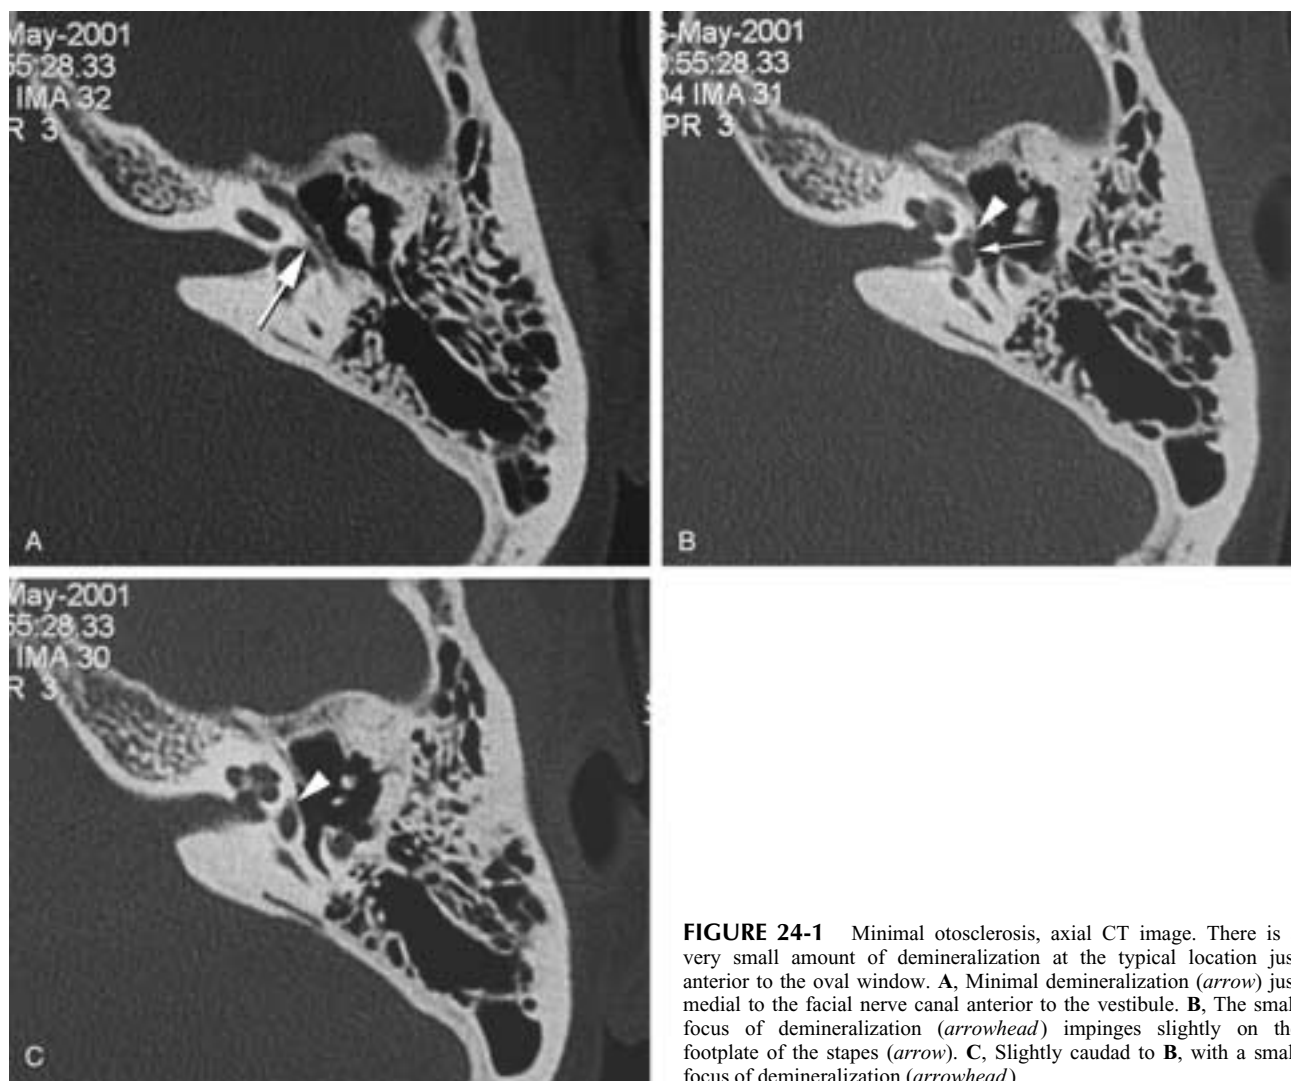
Minimal otosclerosis, axial CT image. There is a very small amount of demineralization at the typical location just anterior to the oval window. A, Minimal demineralization (arrow) just medial to the facial nerve canal anterior to the vestibule. B, The small focus of demineralization (arrowhead) impinges slightly on the footplate of the stapes (arrow). C, Slightly caudad to B, with a small focus of demineralization (arrowhead).
